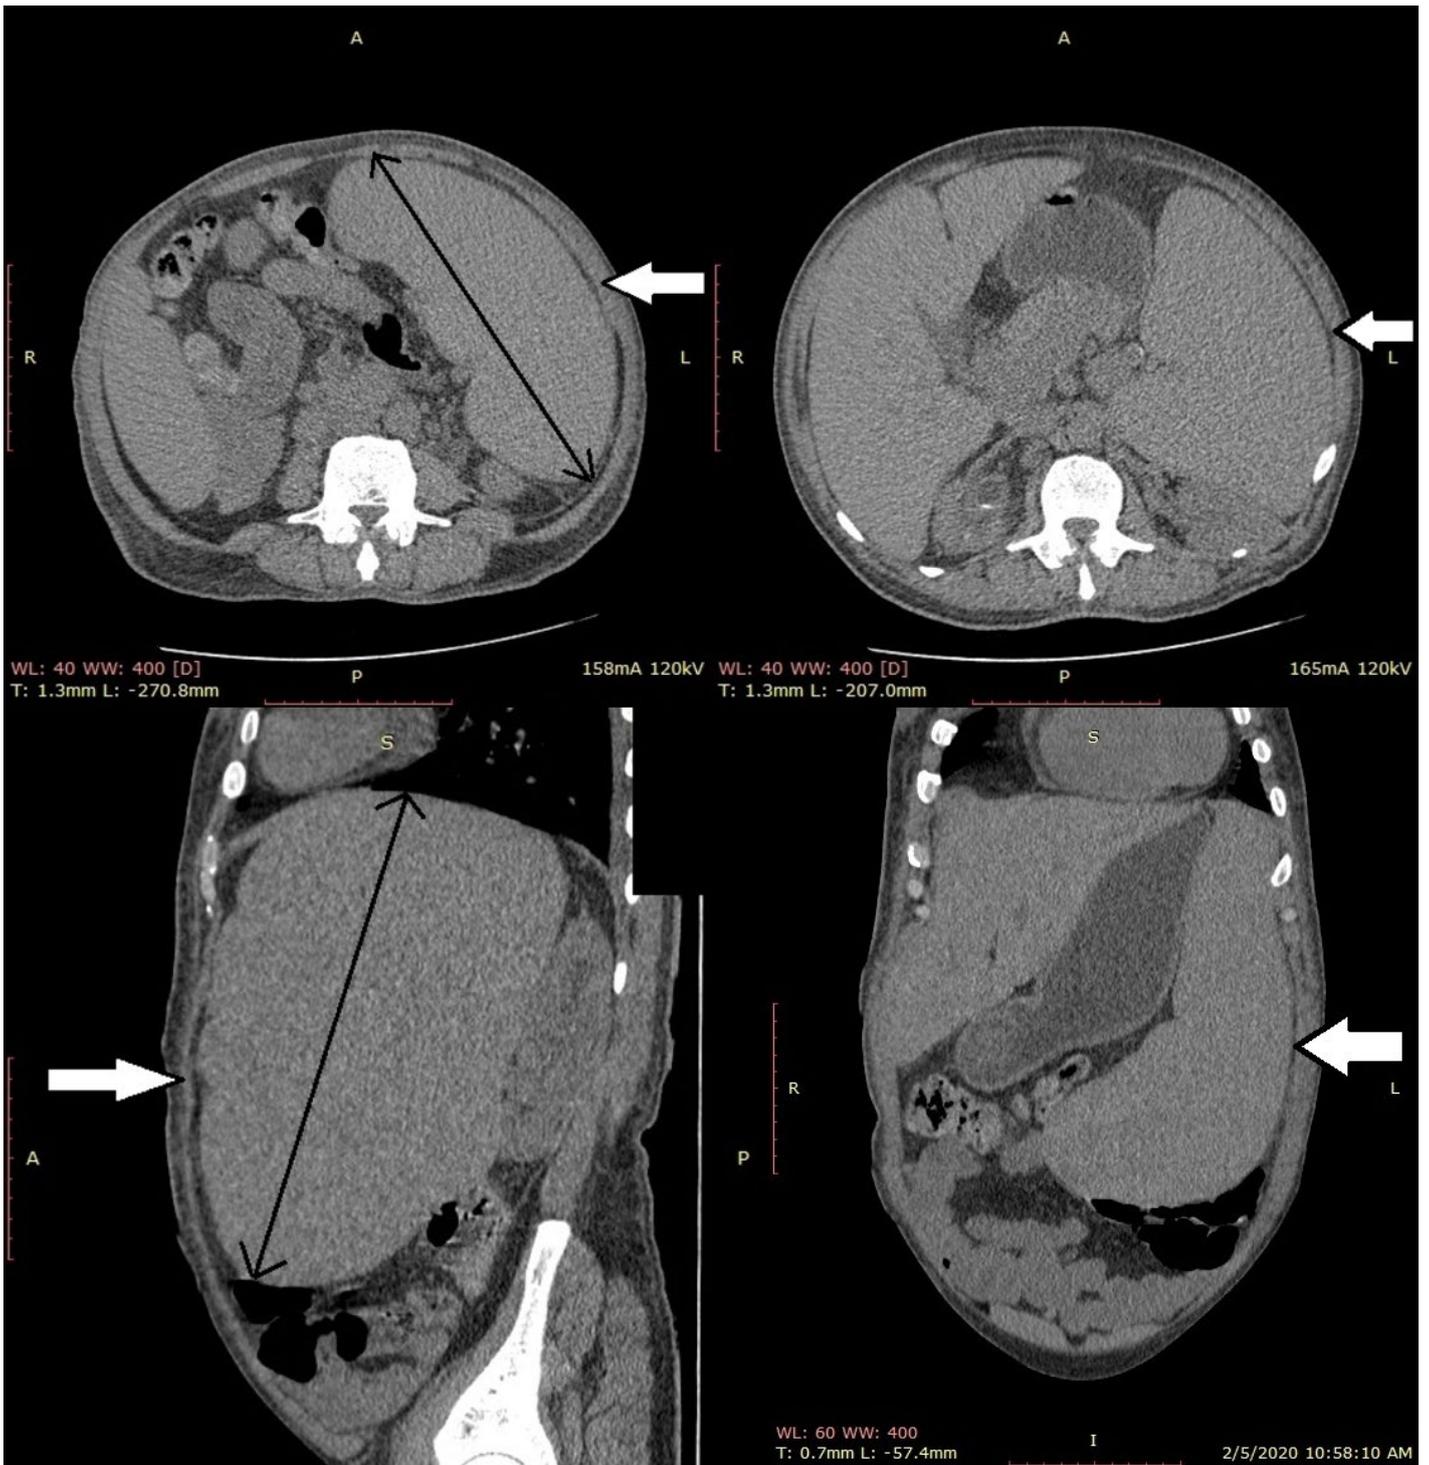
Axial, coronal, and sagittal sections of an abdominal CT scan showing splenomegaly.
